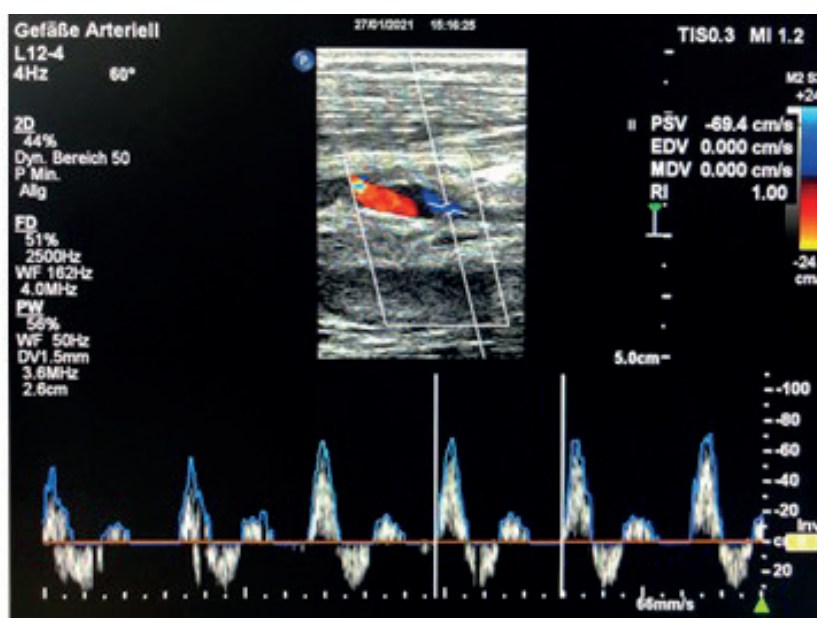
Duplex sonography of the vein graft 16 months post-op.
